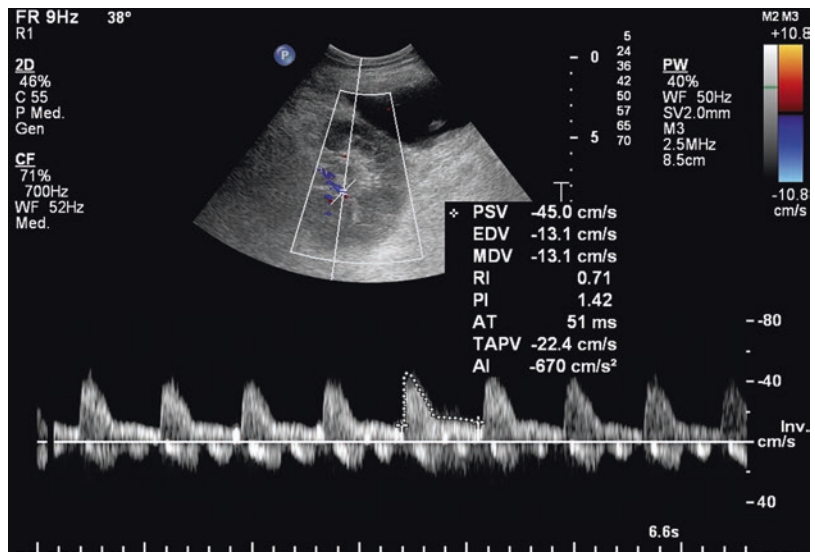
Color Doppler normal spectra of interlobar artery and vein
